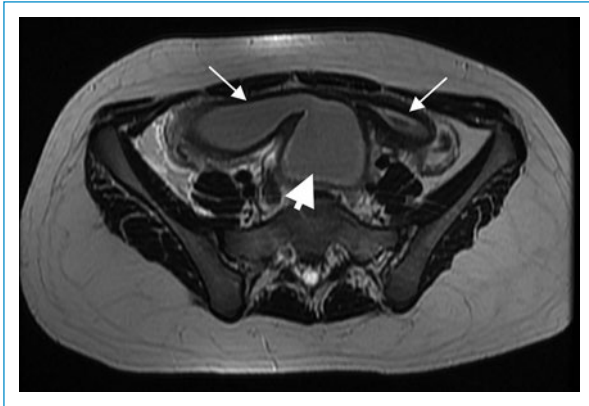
Axial section of magnetic resonance image of the pelvis with contrast showing uterus didelphys, with two uterine cavities (arrows) and what was assumed as the right obstructed hemivagina (large arrow), with a hematometocolpos.
